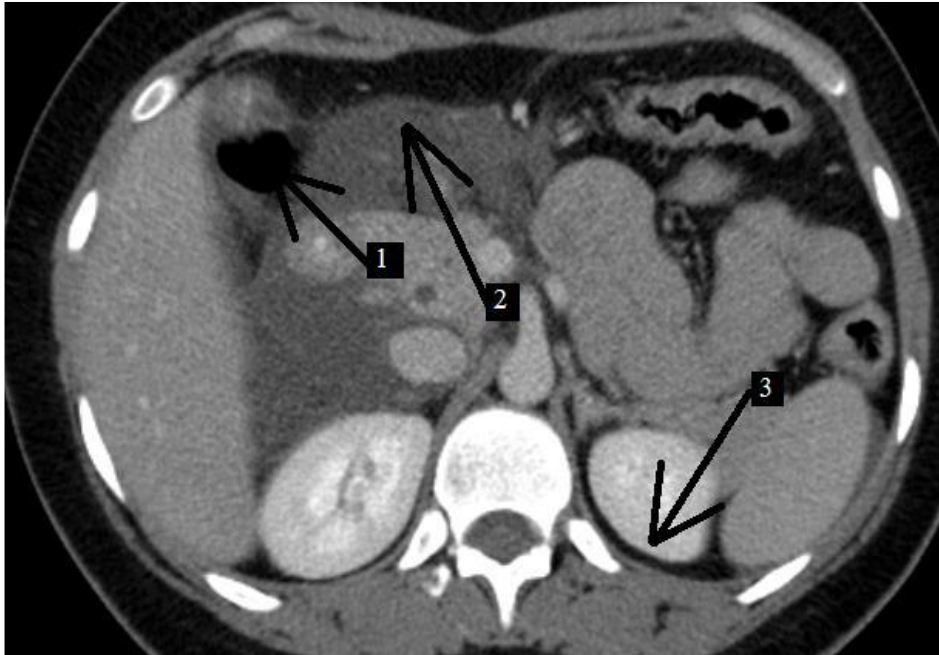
CT scan of the abdominal organs, axial projection. Free gas (1) and liquid (2) in the abdominal cavity and retroperitoneum, paranephric (3) in a patient with a gunshot wound to the abdomen
